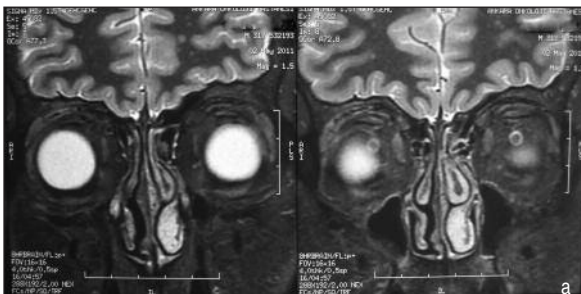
The patient's orbital MRI at eighteen months follow-up.
